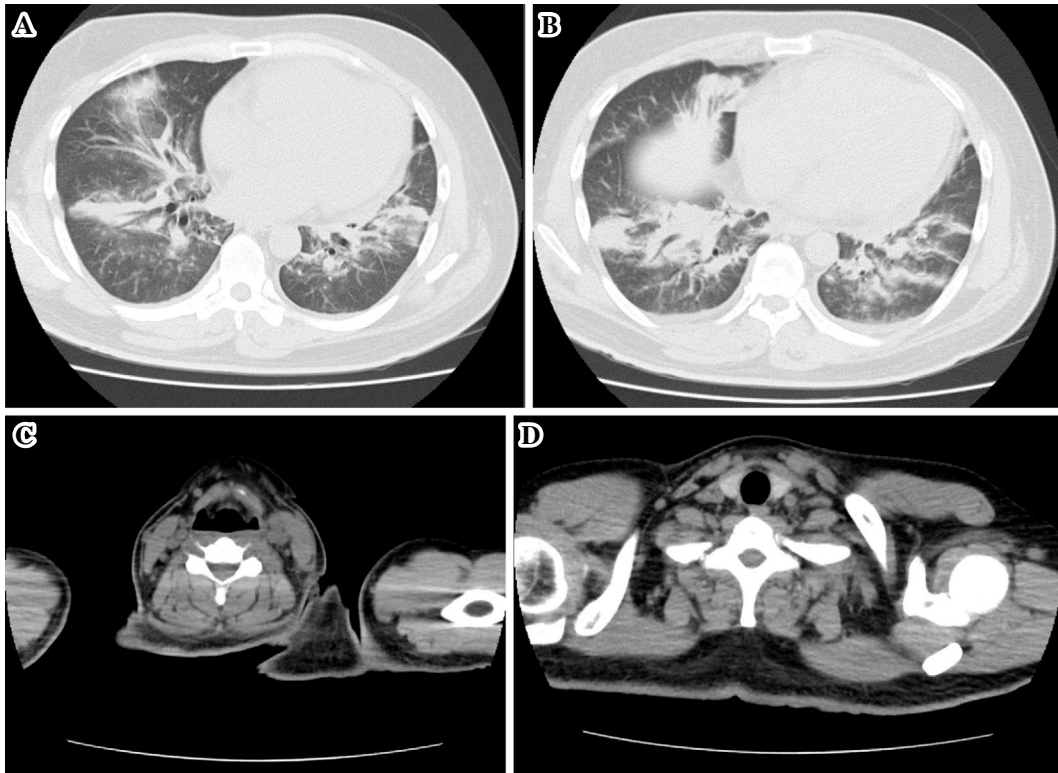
On the sixth day, contrast-enhanced CT revealed airspace consolidation with air bronchograms in the middle lobe of the right lung and lower lobes of both lungs (A, B) and enlargement of the right cervical and supraclavicular lymph nodes (C, D).
